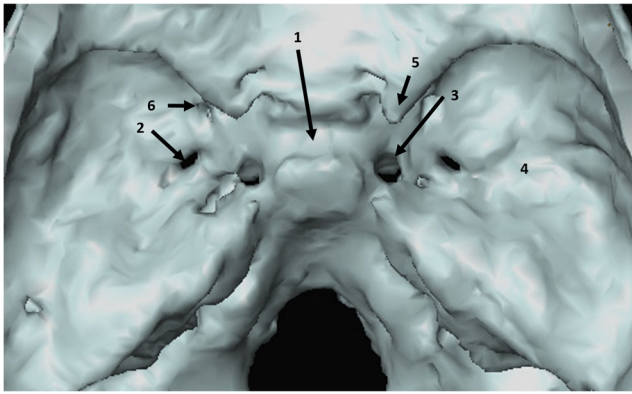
3D CT reconstruction, using Amira® software, displayed the middle cranial fossa with its different structures. The image shows the sella turcica with its hypophyseal fossa (1), foramen ovale (2), carotid canal (3), greater wing (4), anterior clinoid apophysis (5), and foramen rotundum (6)
